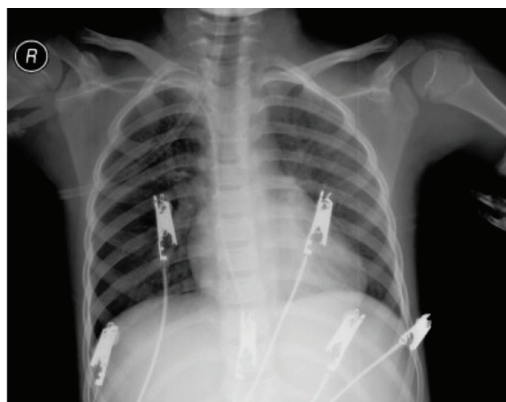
Chest X-ray taken 48 hours after plasmapheresis
